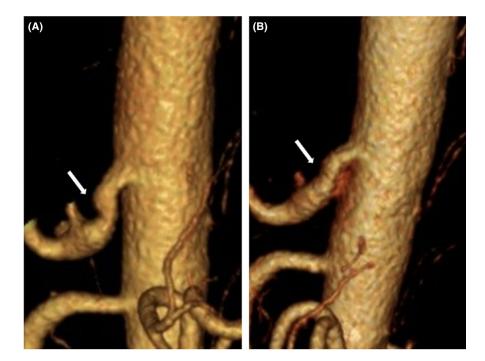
Three-dimensional reconstruction of the enhanced CT images (arrows) showing indentation in the celiac axis, "hooked appearance," during expiration (A) and its release during inspiration (B)
